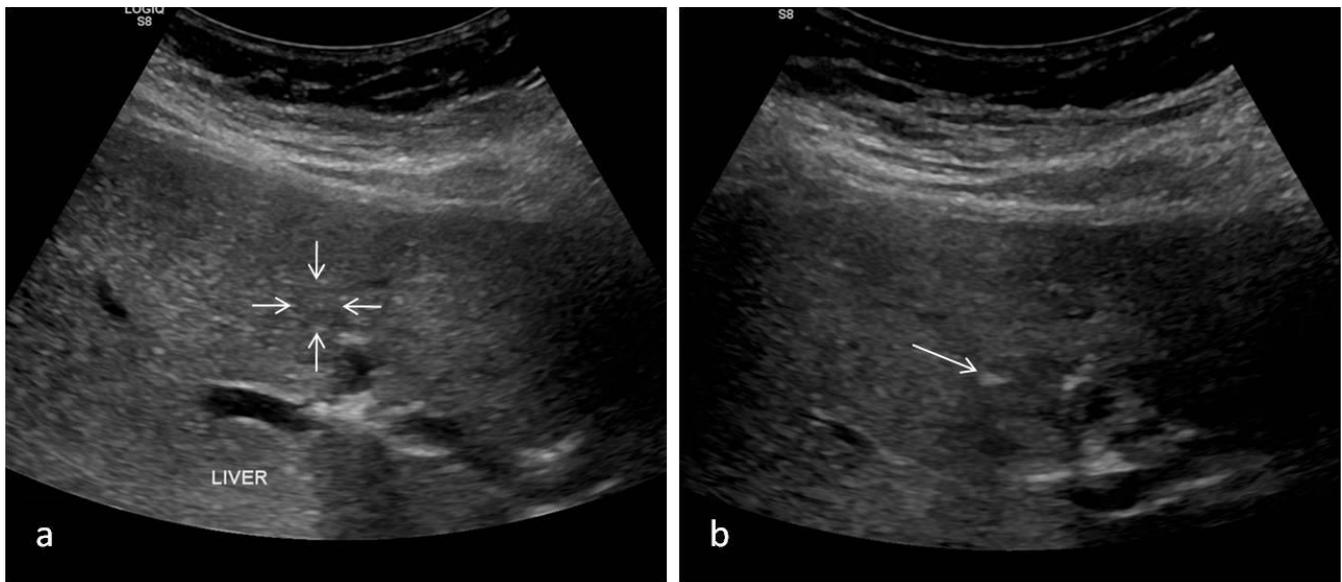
(a) Ultrasound images shows an isoechoic lesion with thin peripheral halo (marked with arrows). (b) USG guided FNAC was done. Arrow shows an echogenic tip of the needle in the liver lesion.
